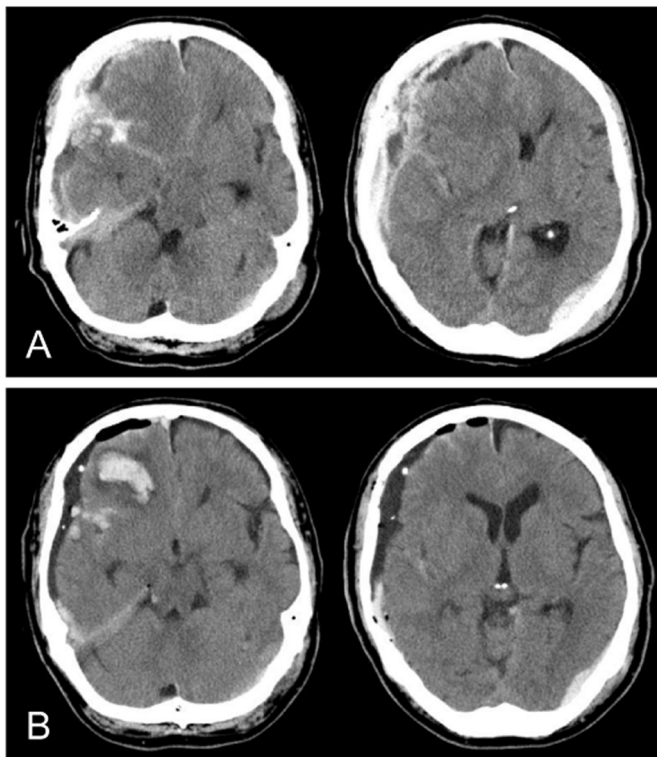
A: CT scans obtained on admission showing a 25-mm right frontotemporal acute subdural hematoma and a marked midline shift. Right frontal contusional hematoma, traumatic subarachnoid hemorrhage in the right sylvian fissure, and acute epidural hematoma located just below the left occipital skull fracture are also recognized. B: Postoperative CT scans demonstrating an obvious reduction in the size of the hematoma and enlargement of contusional hematoma.
